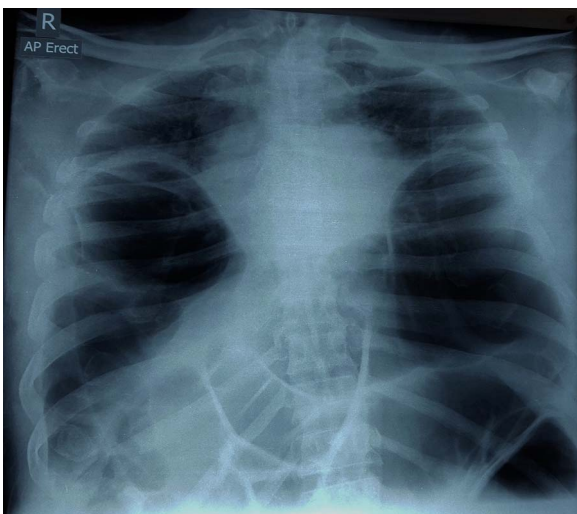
Chest X-ray demonstrating Chilaiditi's sign with bilateral elevated hemidiaphragms and dilated large bowel.
